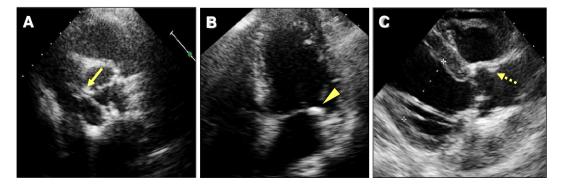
Examples of determining the THC score. Two-dimensional echocardiographic images show aortic valve calcification (A, solid arrow), mitral annular calcification (B, arrowhead), and aortic root calcification (C, broken arrow). THC score was determined by summing these extracoronary calcifications. It was calculated to be 3.
